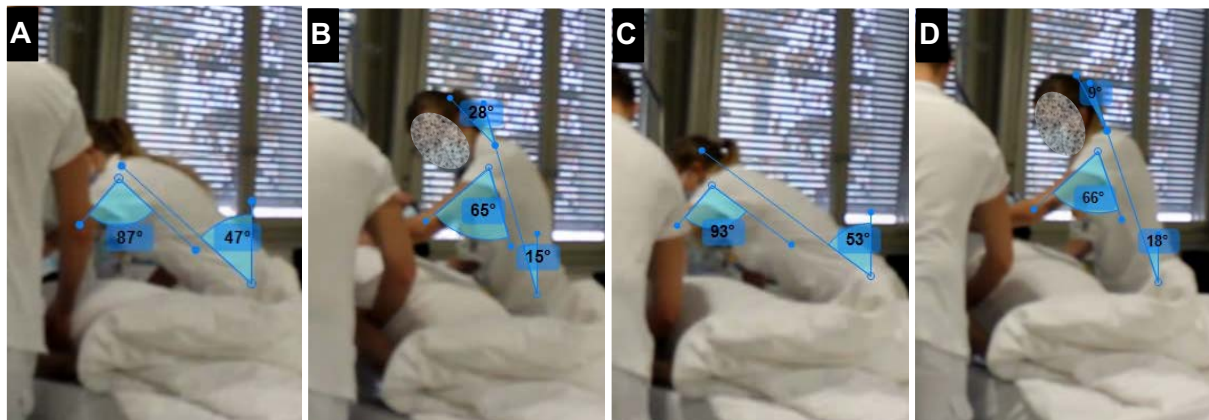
“Not acceptable” postures assumed by the medium radiographer (helper) during bedside chest X-ray examination in scenario 2: a) during the preparation to position the detector under the patient's back; b) during the patient handling to position the detector under the patient's back; c) during the preparation to remove the detector from under the patient's back; d) during the patient handling to remove the detector from under the patient's back.
